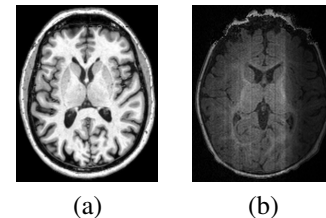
T1-weighted MRI scans for adult (a) and infant (b) brains.
